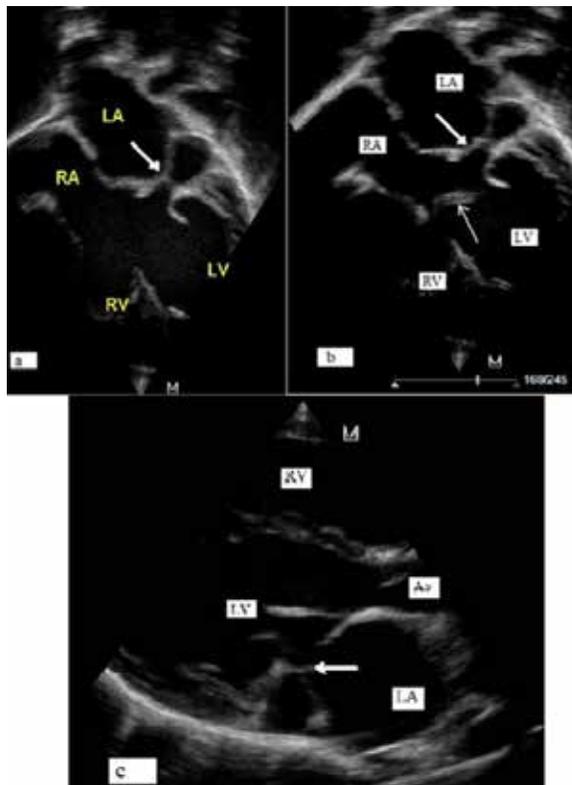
(a) Apical four- chamber view still frame demonstrating complete atrio- ventricular canal and a discrete circumferential membrane (thick arrow). (b) Complete atrio- ventricular canal with bridging leaflet (thin arrow) and a discrete circumferential membrane (thick arrow) attached to the left atrial wall and the left lateral annulus. (c) Parasternal long- axis view still frame demonstrating a discrete circumferential membrane with a central orifice (thick arrow).
